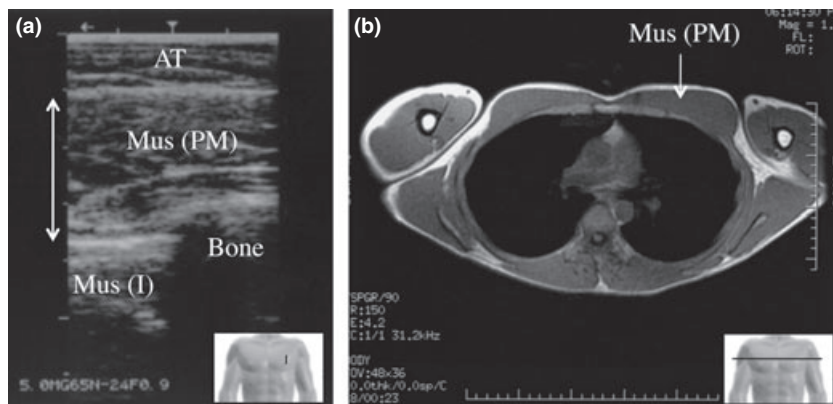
Typical ultrasonographic image (a) and magnetic image showing transverse section (b). Image a is vertical scan on the left of the chest. Image b is transverse scan of the chest. AT, subcutaneous adipose tissue; Mus, skeletal muscle tissue; PM, pectoralis major muscle; I, intercostal internus muscle; Bone, costa.
